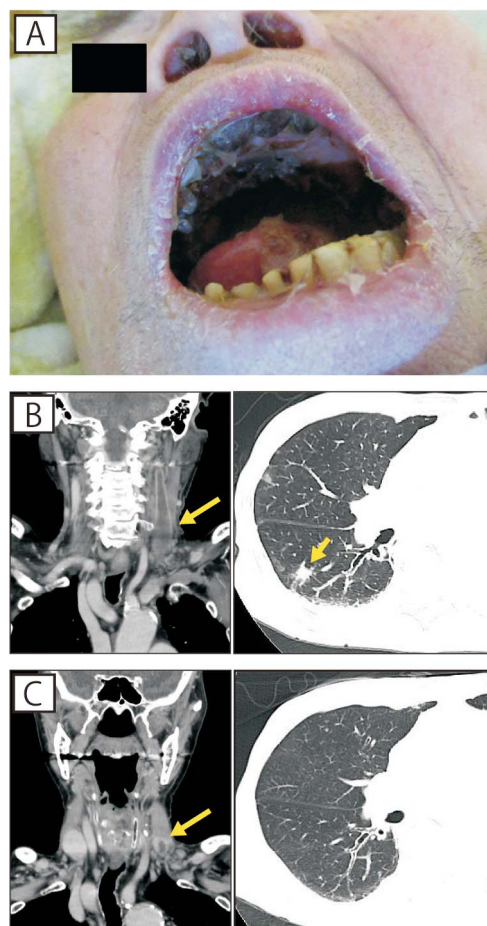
(A) Intra-oral clinical appearance at presentation. (B) Initial contrast-enhanced computed tomography on admission revealed a thrombus in the left internal jugular vein (left panel) and multiple irregular peripheral pulmonary nodules (right panel). (C) Contrast-enhanced computed tomography following 4-weeks administration of ceftriaxone and heparin revealed shrinkage of the thrombus (left panel) and disappearance of the pulmonary nodules (right panel).
